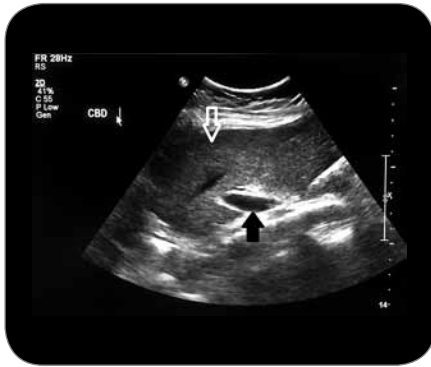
Normal liver (white arrow) ultrasound scan showing common bile duct (black arrow).
